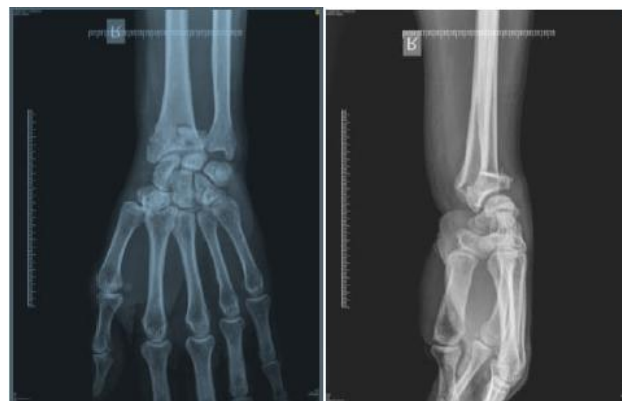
Pre-op AP and lateral X-ray.
